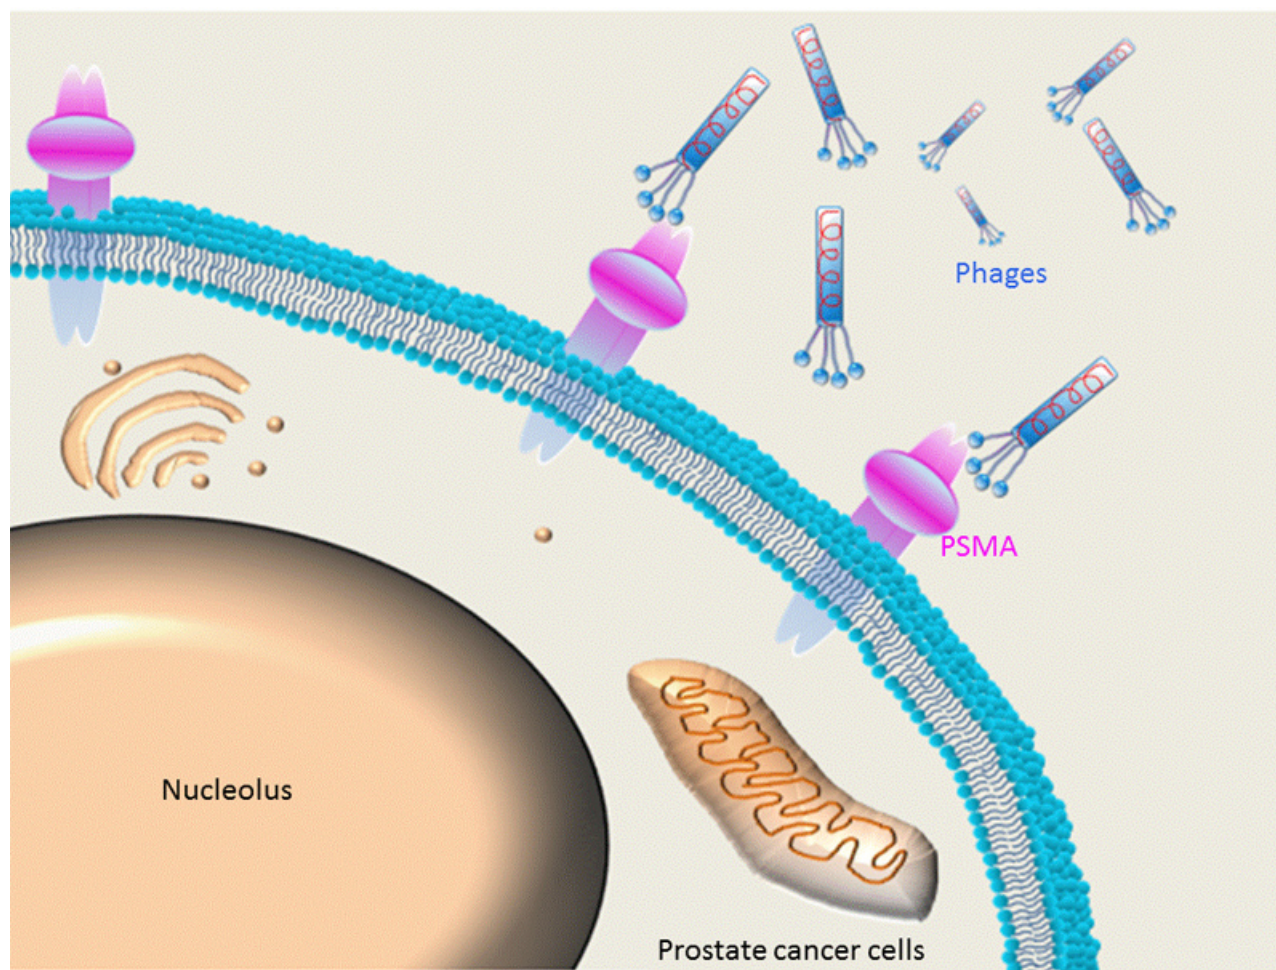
Binding of phages (a type of bacterial viruses) to PSMA on prostate cancer cells.
